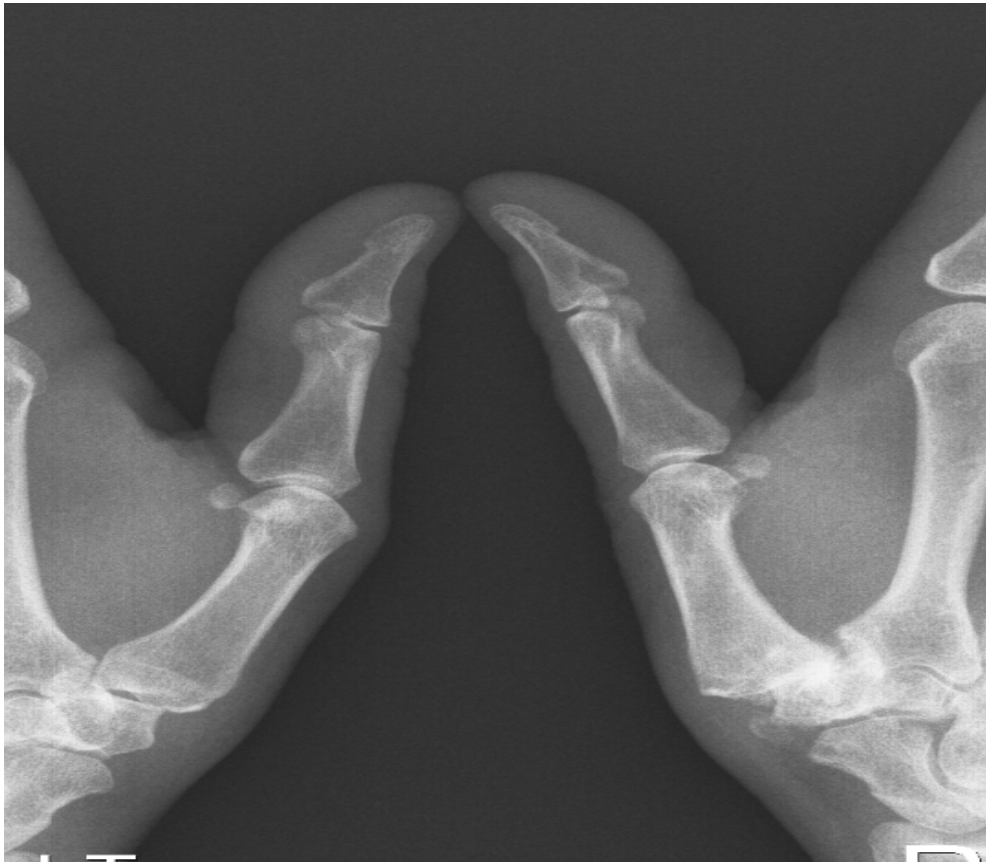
Plain radiograph showing Eaton Stage III osteoarthritis of the trapeziometacarpal joint of the right thumb
